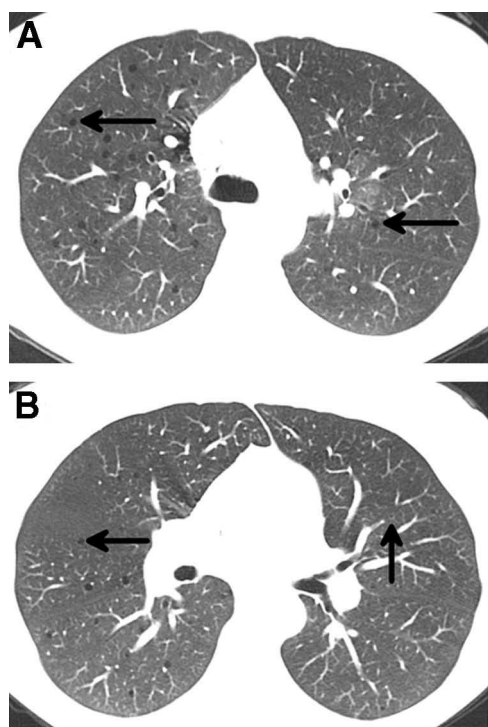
Axial computed tomography (CT) chest (lung window) showing regression of solid and cavitating pulmonary metastases to pneumatoceles (arrows) at (A) carinal and (B) subcarinal levels.
